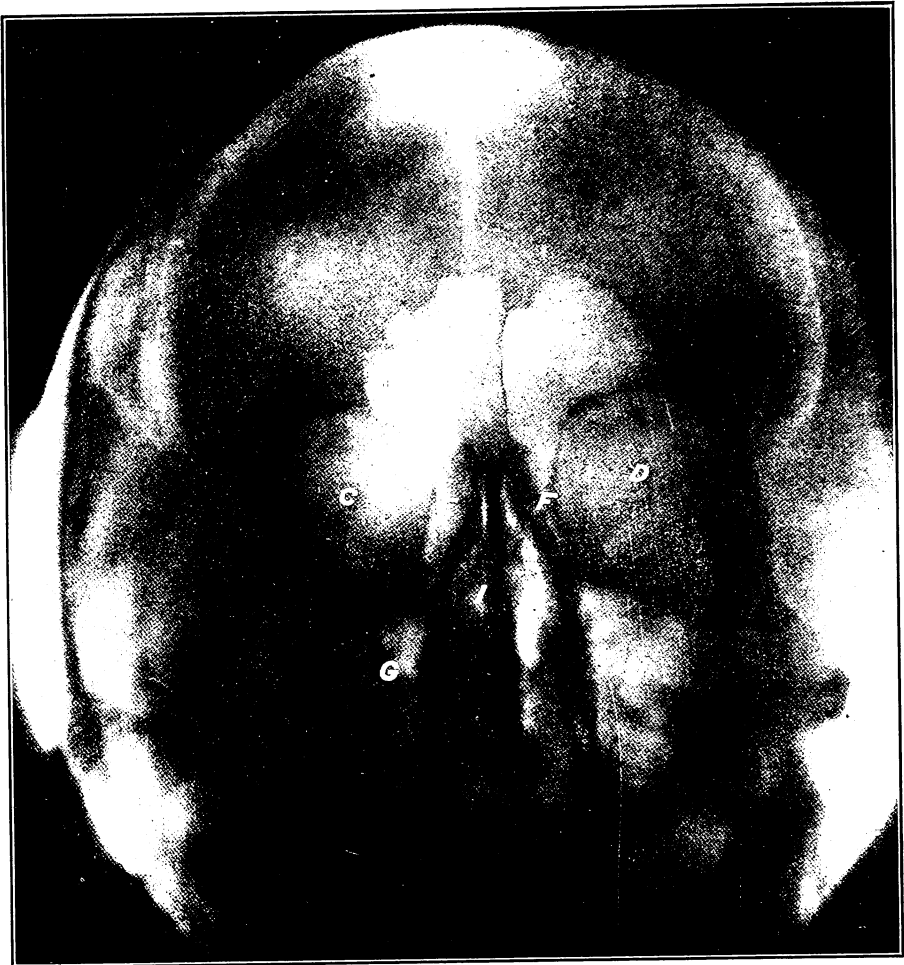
Radiograph made from the pose shown in figure 104. A. B. frontal sinuses. C. D. orbits. E. F. ethmoidal cells. F does not show as well as E because the cells of this side are full of pus. G. H. antra of Highmore. I. J. nasal cavity. As an aid in reading this radiograph observe figure 106. (Radiograph by A. M. Cole, of Indianapolis.)
